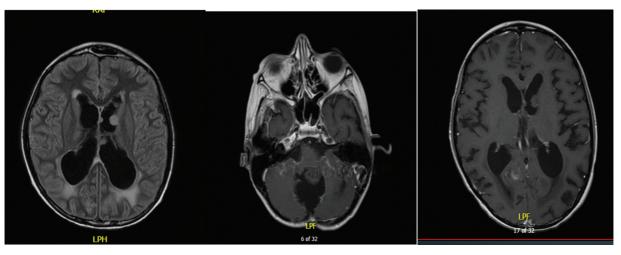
Magnetic resonance imaging with contrast showing recurrence of a cerebellar medulloblastoma with metastatic subependymal nodules.
